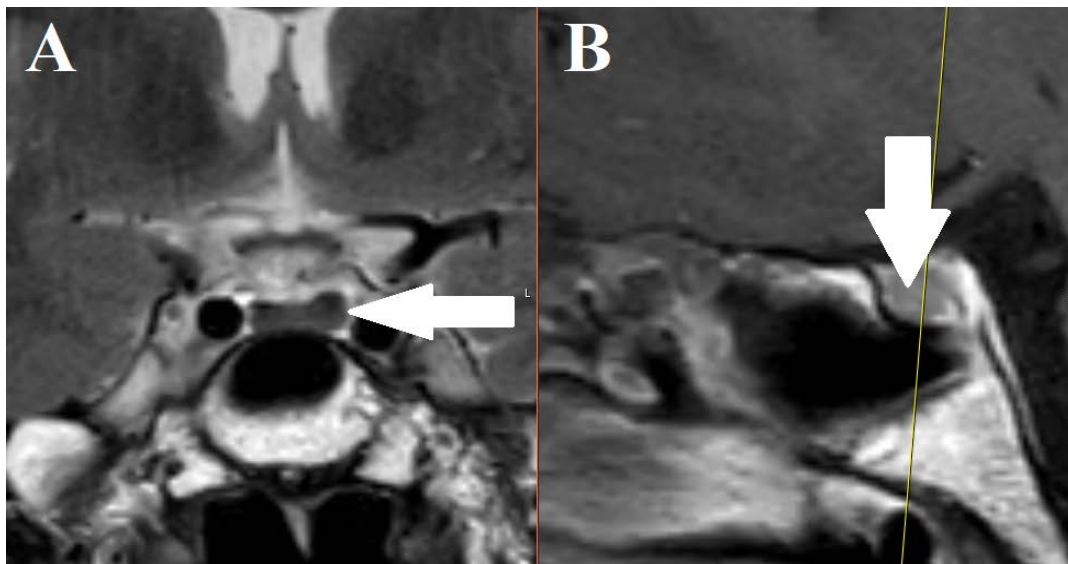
In the left lateral aspect of the adenohypophysis (A, B), an irregular T2-weighted hypointense lesion (arrow), measuring 3 x 5 mm, is observed. The lesion demonstrates delayed post-contrast enhancement and is consistent with a pituitary microadenoma
